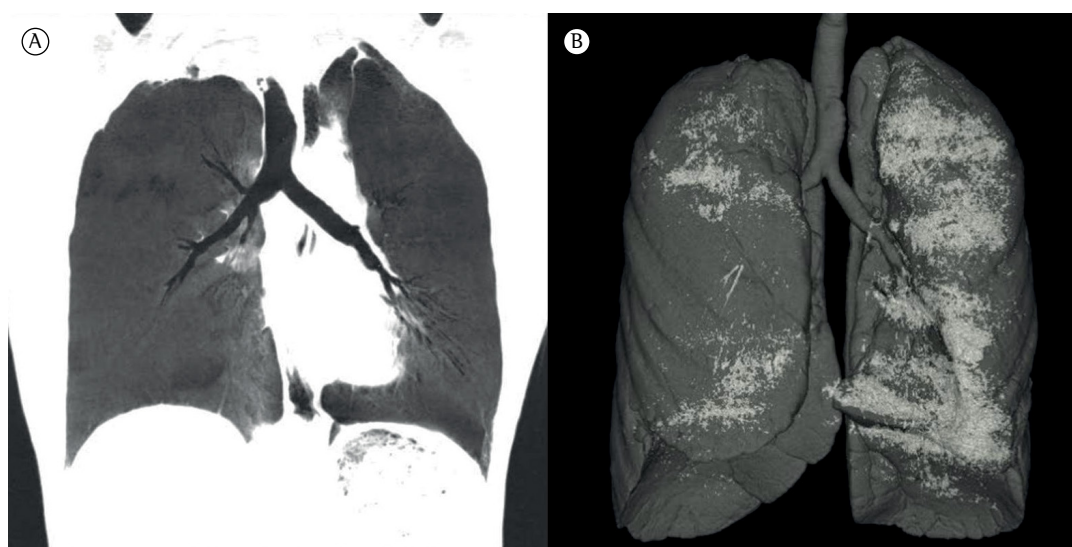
In A, coronal reformatted CT image (minimum intensity projection) showing air trapping. In B, three-dimensional CT reconstruction showing low attenuation volumes, which represent air trapping volumes.
